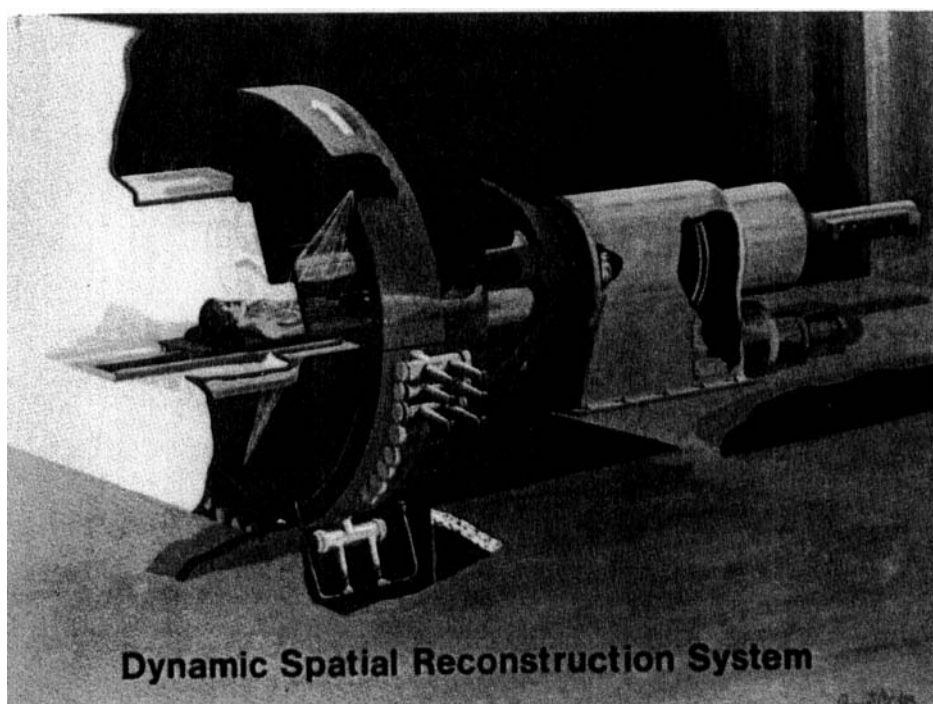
Artist's conception of DSR. Twenty-eight independent computer-controlled rotating anode X-ray sources are positioned around the lower-half circumference of the gantry ring. Each X-ray beam, when pulsed on for 0.35 msec, passes through the subject to create an X-ray transmission image on a portion of curved fluorescent screen. Each image of the total set of 28 transmission images generated in 10 msec at the rate of 60 sets/sec is scanned by its opposing video camera chain, 28 of which are mounted on the upper-half circumference of the gantry. The cantilever-supported gantry rotates continuously at about 15 r/min such that a greater range and number of multiplanar views are available when increased spatial and density resolution are needed at the expense of a decrease in temporal resolution; power and electronic signals pass through slip rings at the far end of the gantry mechanism. (Reproduced from Wood, E. H., et al., Third Symposium on Coronary Heart Disease, in press. With permission.)
